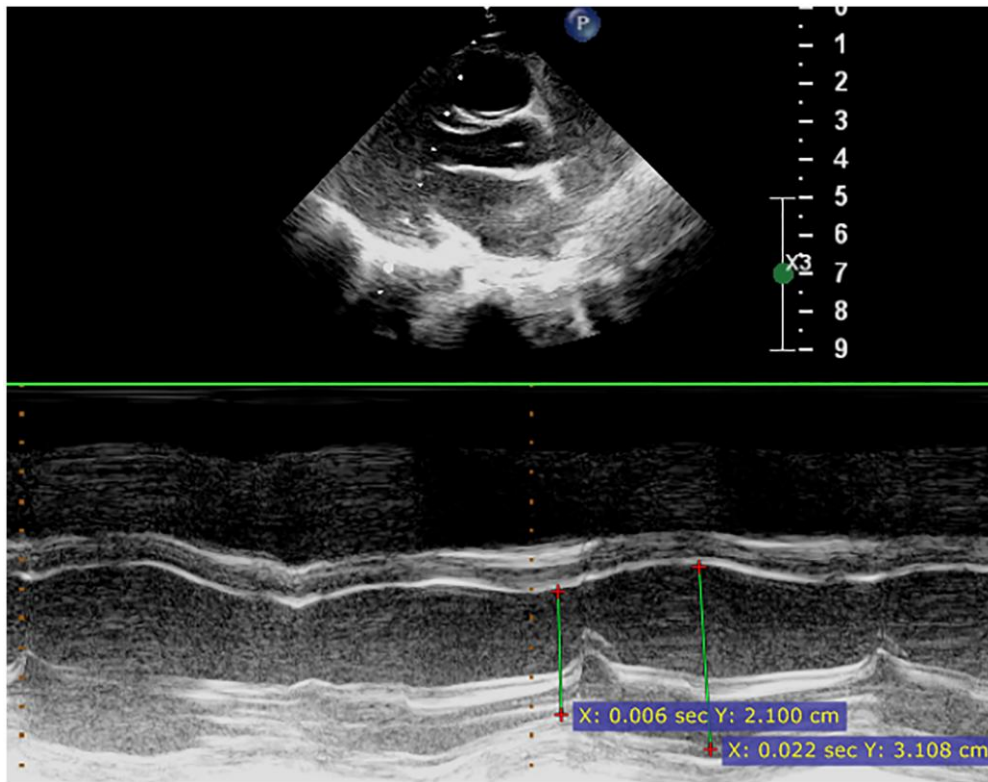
Echo on discharge. Parasternal long axis, M Mode.
